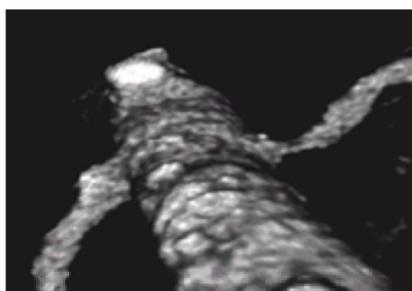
An upward view of a spiral computed tomographic angiogram demonstrating proximal left renal artery atherosclerotic stenosis.
